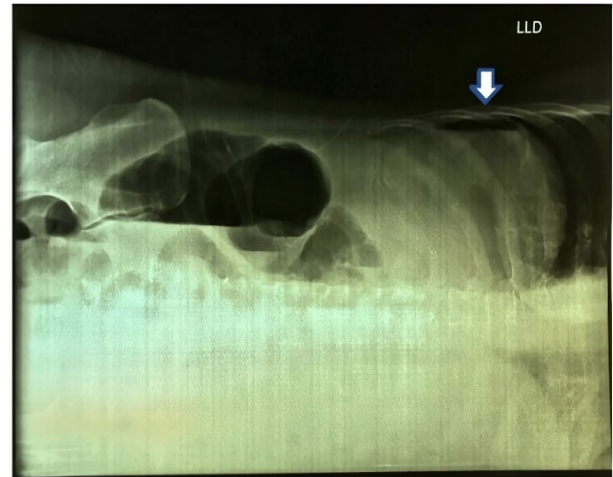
Left lateral decubitus plain abdominal X-ray displays free air (indicated by the white arrow) and blurring of the preperitoneal fat line. (X-ray conducted at Jepara District Hospital during the patient's second admission), consistent with pneumoperitoneum due to hollow viscus perforation.
